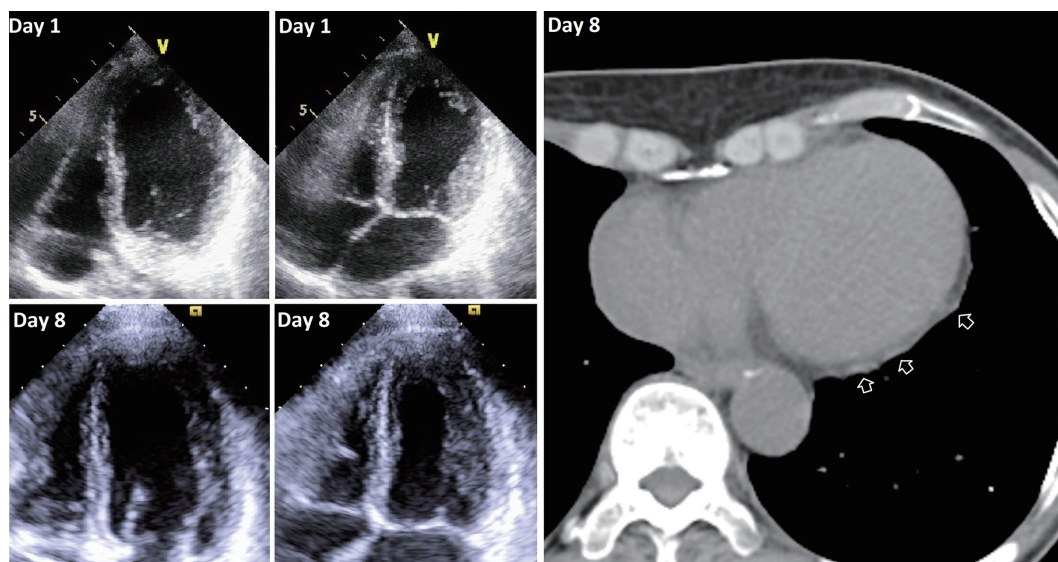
Echocardiography and the first computed tomography.
